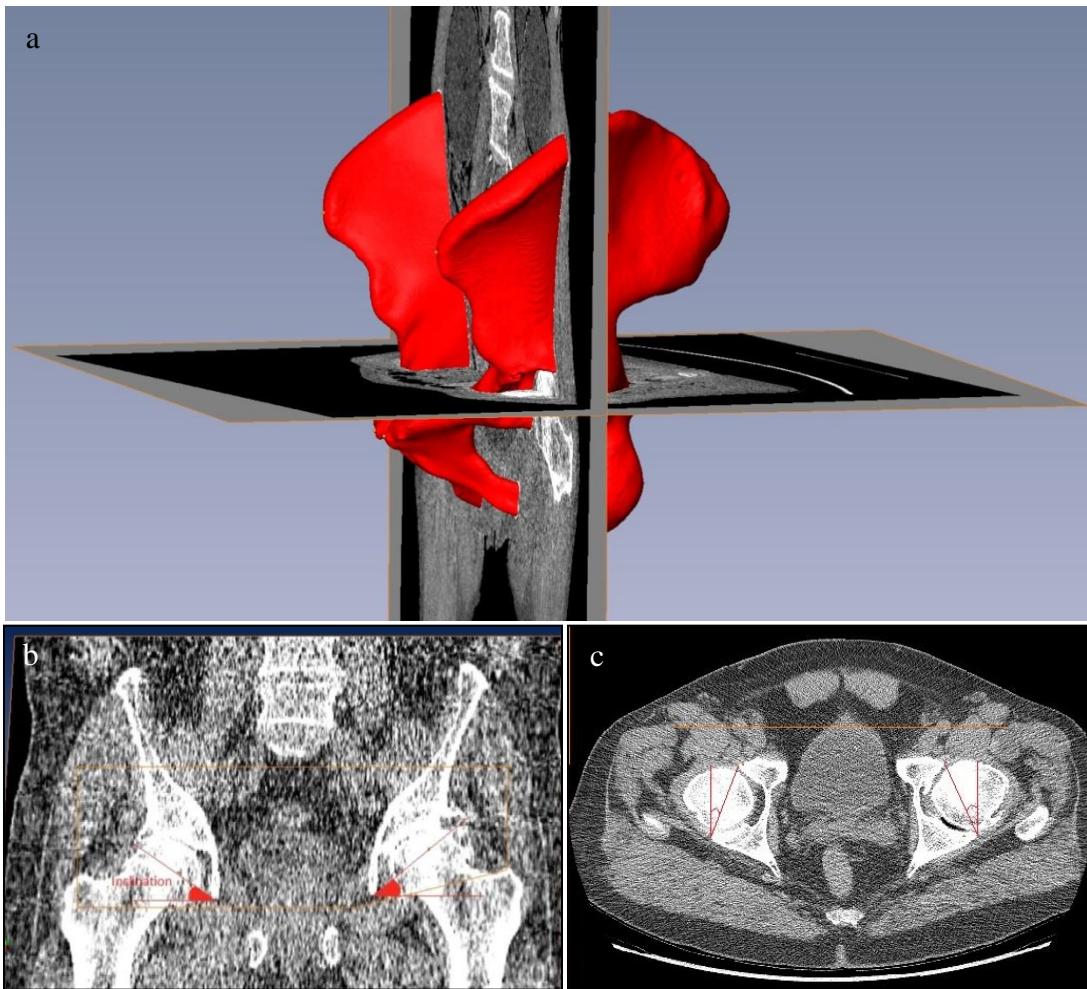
Preplanning the inclination and version offsets on a pelvis CT scan.
